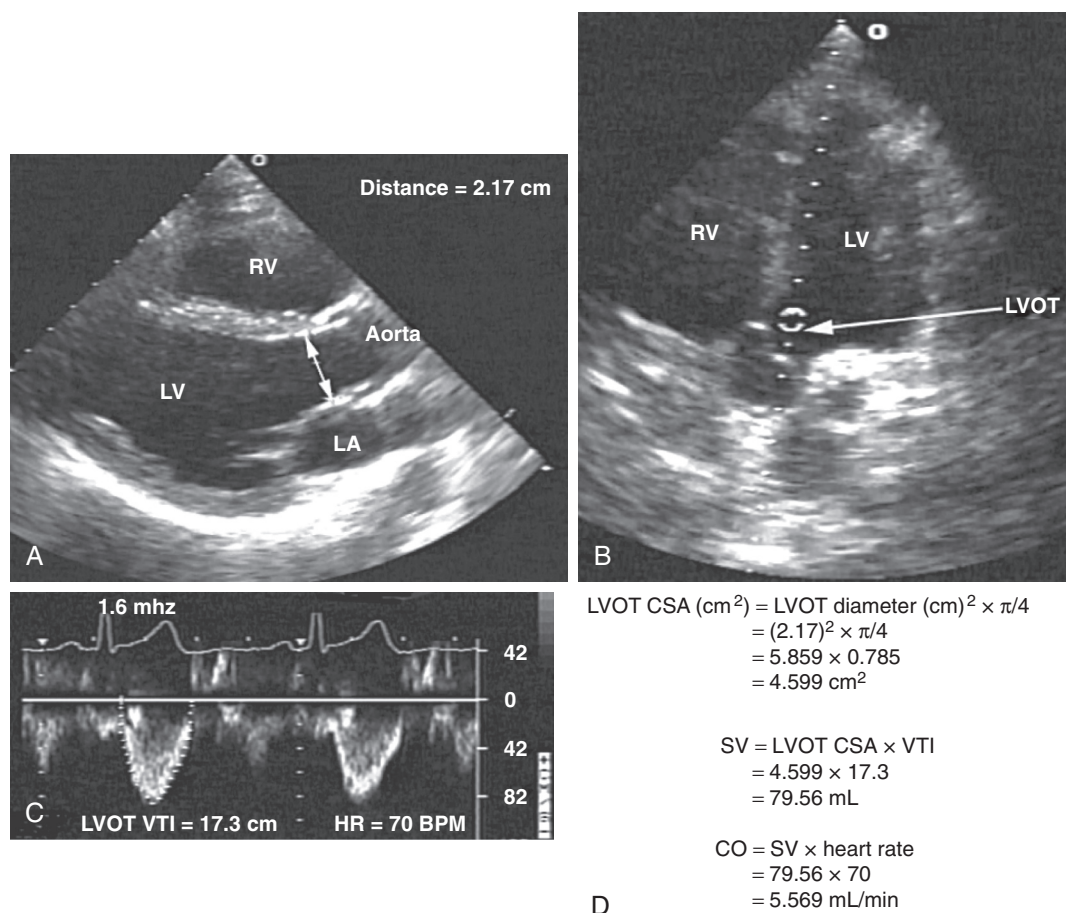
■ Calculation of the stroke volume and cardiac output from the left ventricular outflow tract (LVOT). A, Left ventricular outflow tract diameter obtained from the transthoracic parasternal long-axis view, just below the insertion of the aortic valve leaflets. In this example, the left ventricular outflow tract diameter is 2.17 cm. B, Doppler interrogation (with pulsed wave Doppler) is performed from the apical view with the sample volume being placed in the left ventricular outflow tract, just below the aortic valve. C, Spectral Doppler tracing from the left ventricular outflow tract from which the transaortic flow velocity time integral (VTI) is derived. In this example, the VTI is 17.3 cm. D, The left ventricular stroke volume (SV) is obtained by measuring the cross-sectional area (CSA) of the left ventricular outflow tract (area [cm²] = left ventricular outflow tract diameter [cm]² × $\pi/4$) and multiplying by the transaortic VTI derived from the spectral Doppler tracing. The stroke volume is obtained by multiplying the heart rate to give the cardiac output (CO). LA, left atrium; LV, left ventricle; RV, right ventricle.
